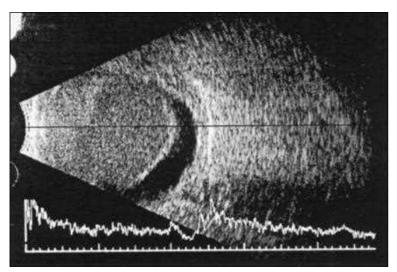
B-scan ultrasonography picture of a suprachoroidal hemorrhage.
